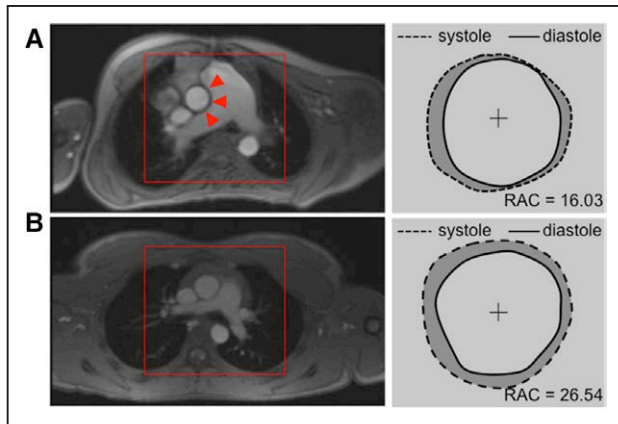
Pulmonary artery impingement on aorta. A, On this representative pediatric pulmonary arterial hypertension (PAH) patient, one can immediately notice a severely dilated main pulmonary artery (MPA) impinging on the ascending aorta. Wall deformation analysis from segmented PC-MRI magnitude images shows reduced range of motion along the aortic-MPA interface highlighted by red triangles. B, Conversely, representative control subject reveals size proportional vessel and uniform aortic expansion along the central axis. MRI indicates magnetic resonance imaging; and RAC, relative area change.
